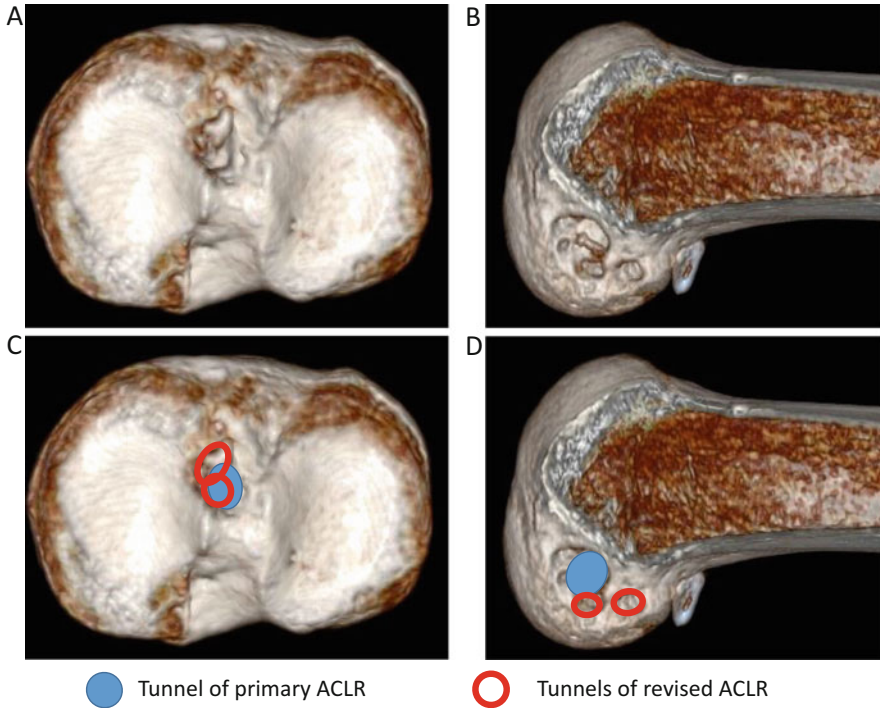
Revision after a nonanatomic anteriorly created femoral tunnel. (a, b) 3-D CT presentation of tibial and femoral tunnel post-revision surgery. (c, d) Tunnel of the primary surgery and tunnels of the revision surgery are indicated by the *blue area* and *red circles*, respectively
